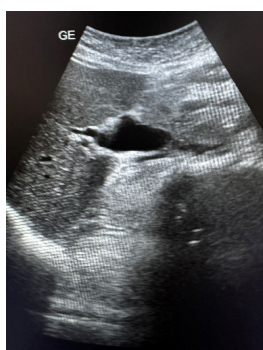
Ultrasound image showing fusiform dilatation of proximal CBD representing choledochal cyst
